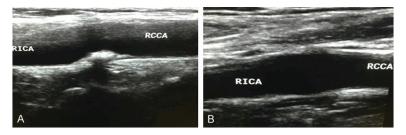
Cervical vascular color ultrasonic inspection (CVUS) performance of the patients before (A) and after treatment (B). Results showed fewer vulnerable plaques and more stable plaques after treatment.
